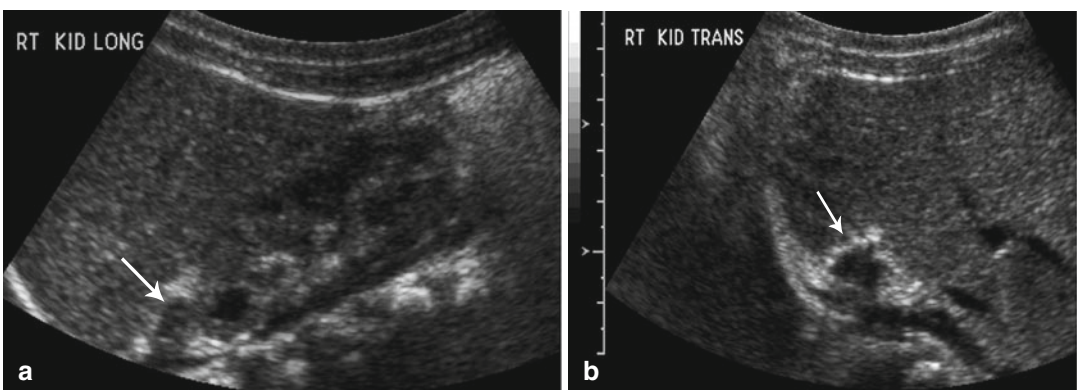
Resolving adrenal hemorrhage. Follow-up longitudinal (a) and transverse (b) ultrasound images (obtained 2 weeks after the images shown in Fig. 16.8) reveal
